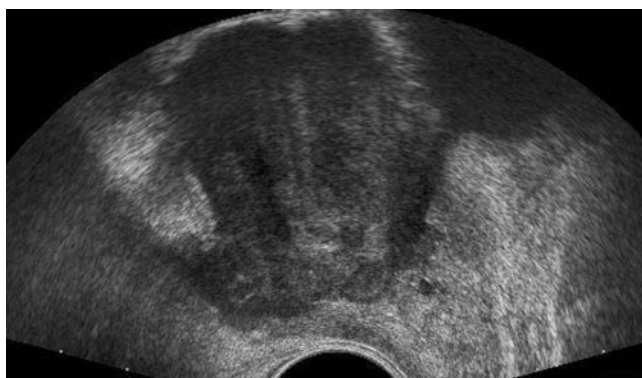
A 36-year-old presented with voiding difficulty. His prostate-specific antigen level was 5.9 ng ml^{-1} . A heterogeneous signal intensity mass compressing the bladder is noted on T_2 weighted axial image. Transrectal ultrasound biopsy revealed synovial sarcoma.
